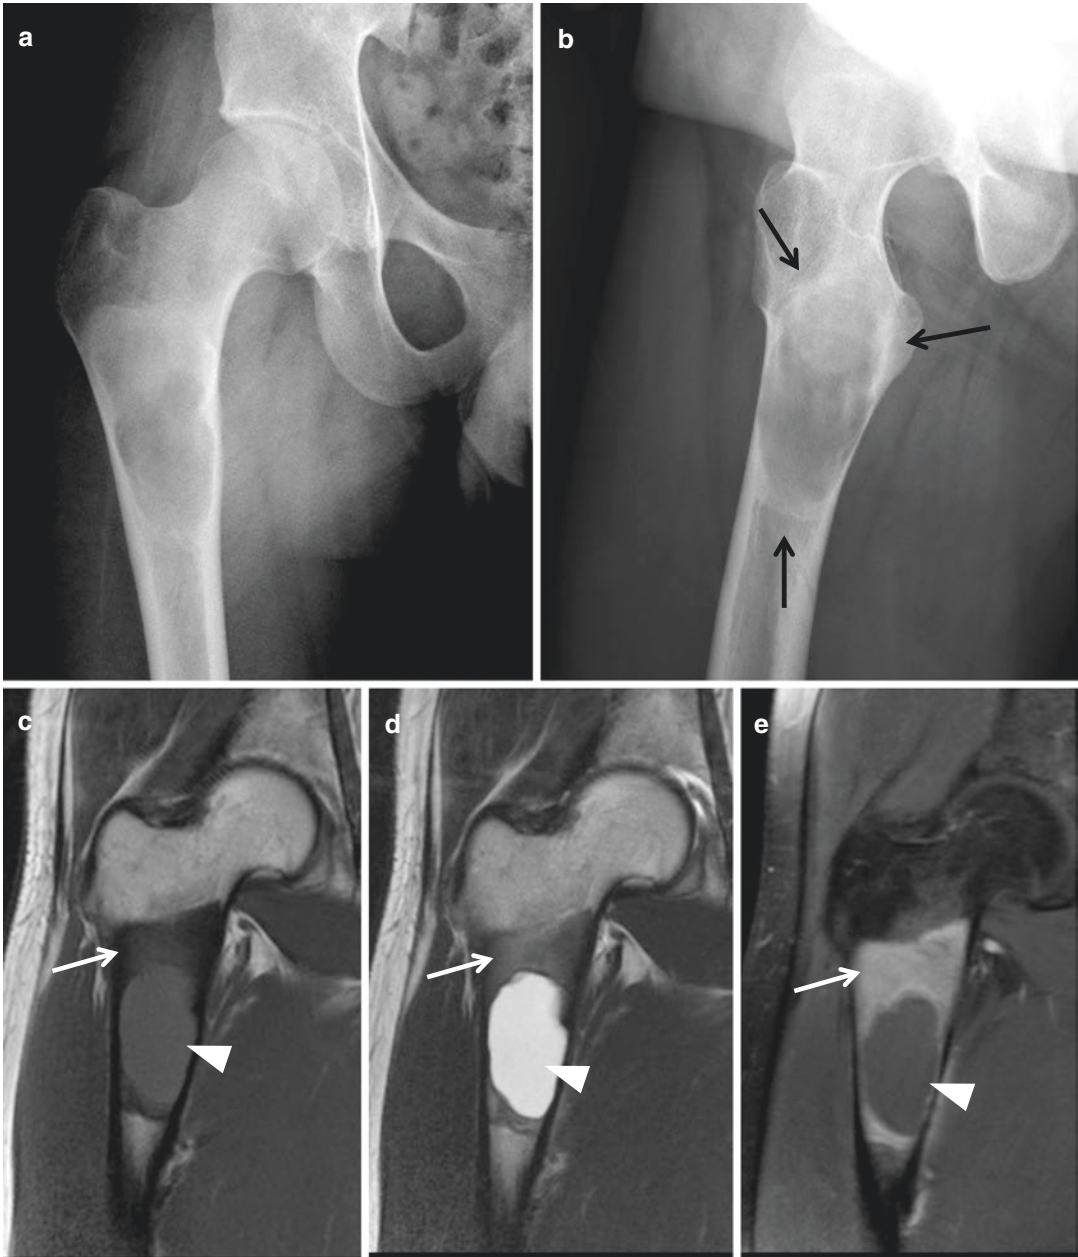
Monostotic fibrous dysplasia in the left femur. (a) Anteroposterior radiograph of the left hip shows a ground-glass opacity lesion in the proximal metaphysis of the left femur in a 9-year-old male. A thin sclerotic rim is noted around the lesion (*black arrows*). (b) The patient presented with a pathological fracture after a minor
